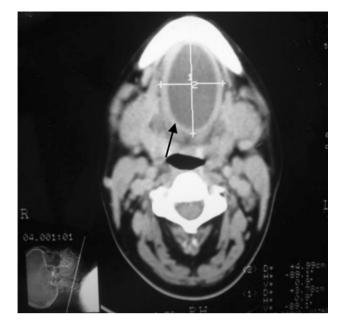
Pre operative CT scan showing oval shaped cystic mass lesion measured $4.9 \times 3.7 \times 5.1$ cm in midline, in the floor of the mouth extending bilaterally from chin to the hyoid bone
